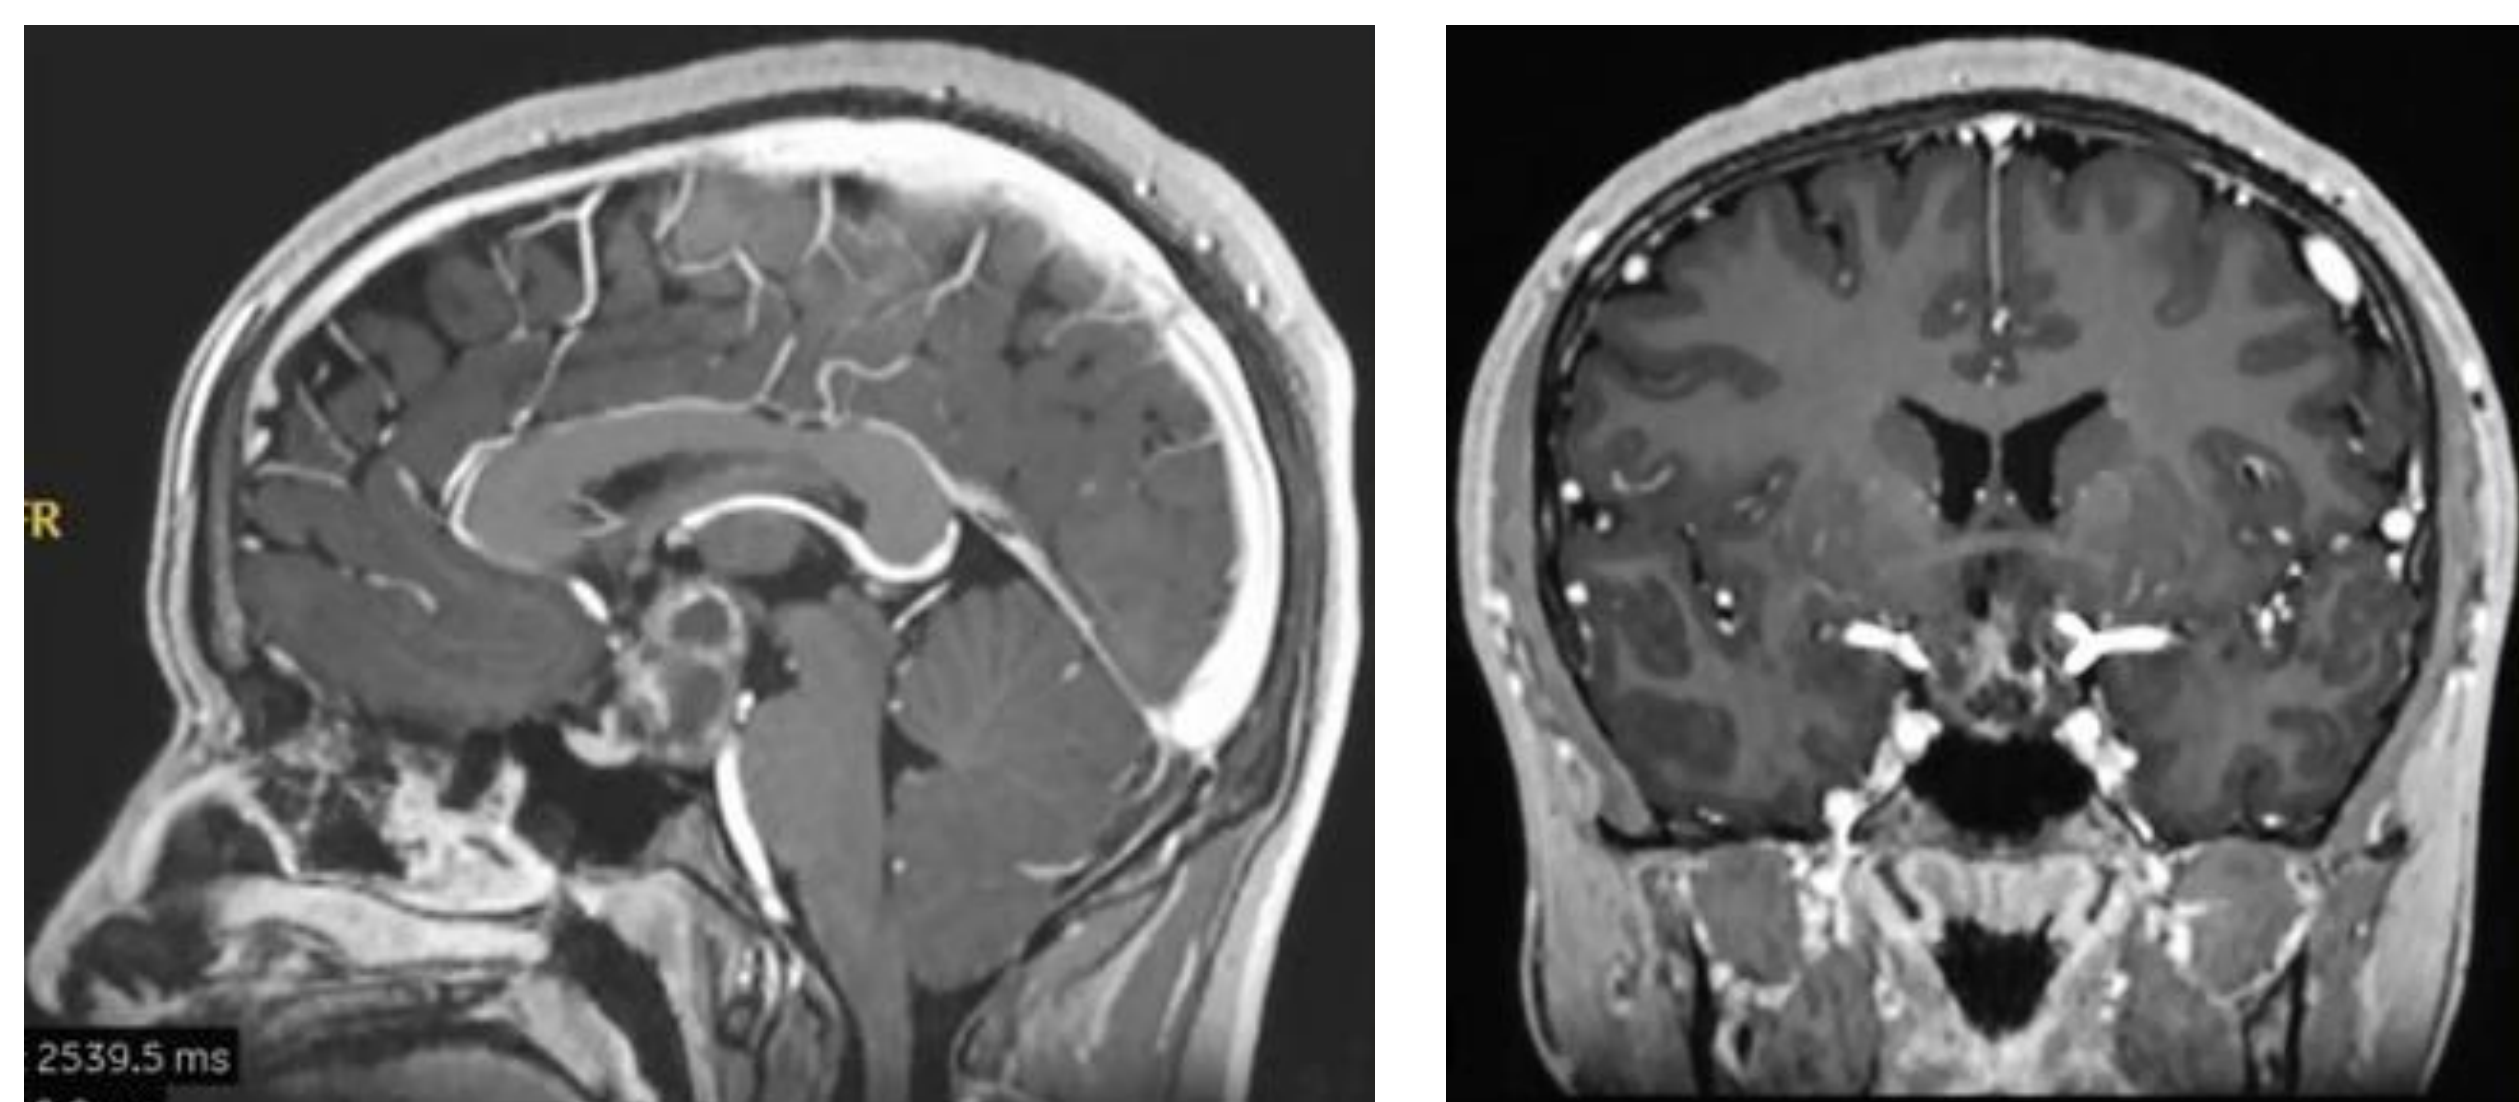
Preoperative MRI.
